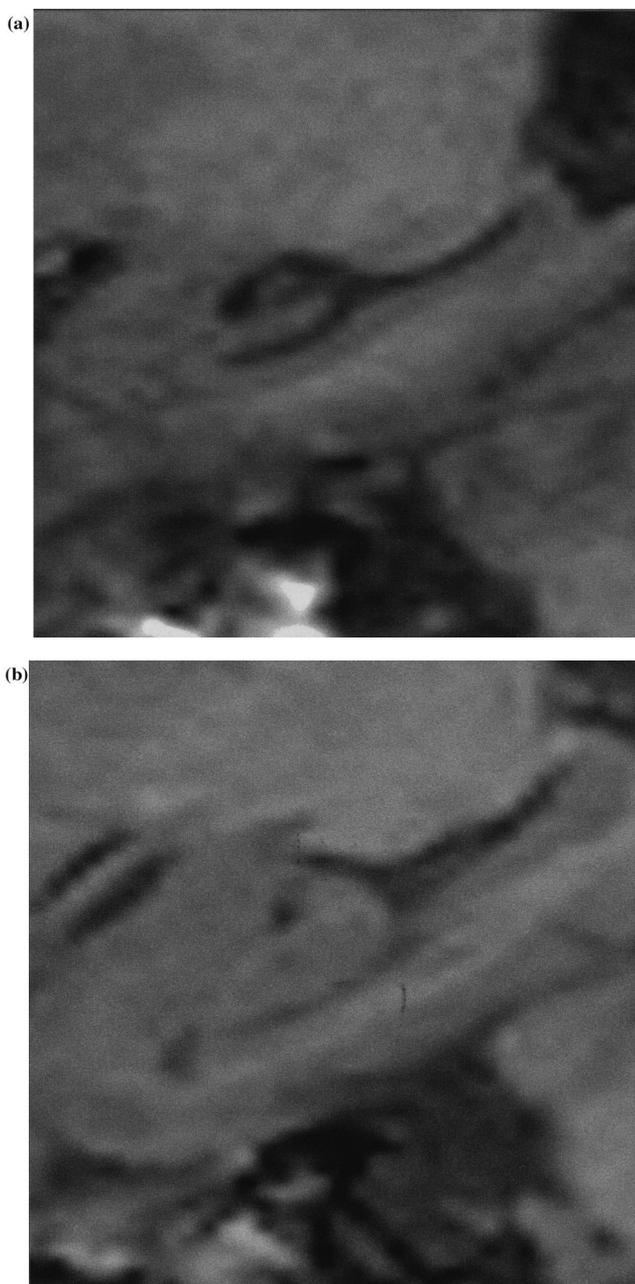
Mid-sagittal sections through the left hippocampus of VC (a) and control subject (b) (T1-weighted MRI). In VC the uncal sulcus is prominent and there is a reduction in size along the entire length of the hippocampus.
